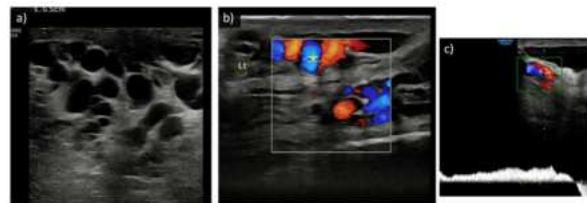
Varicocele a) dilated tubular channels in the cord, diameter measuring more than 2 mm. b) dilated channels showing color fill on color Doppler s/o reflux. c) dilated channels on spectral Doppler show persistent reflux
